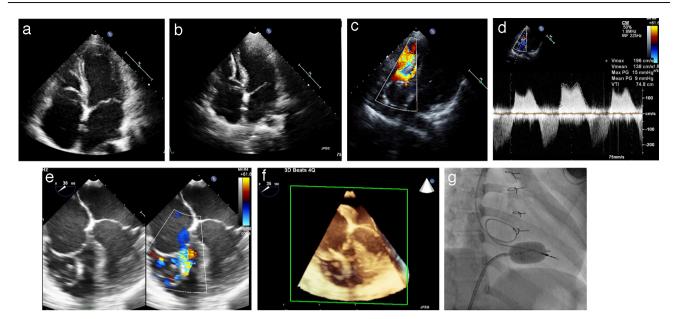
(a) Transthoracic echocardiography in apical four-chamber view demonstrating a thickened tricuspid valve with diastolic doming with the in situ ventricular lead better visualized at slight angulated view. (b and c) Transthoracic echocardiographic with color flow mapping showing turbulence across the tricuspid valve as two jets on either side of the ventricular lead. (d) Continuous Doppler interrogation across the tricuspid valve demonstrating high gradients. (e) Transesophageal echocardiography image in four-chamber view showing thickened and doming tricuspid valve with in situ ventricular lead with 3D reconstruction. (f and g) Fluoroscopic image in right 30° angulation demonstrating inflated balloon across the tricuspid valve. Also seen is the ventricular-lead loop in atria at tricuspid.
